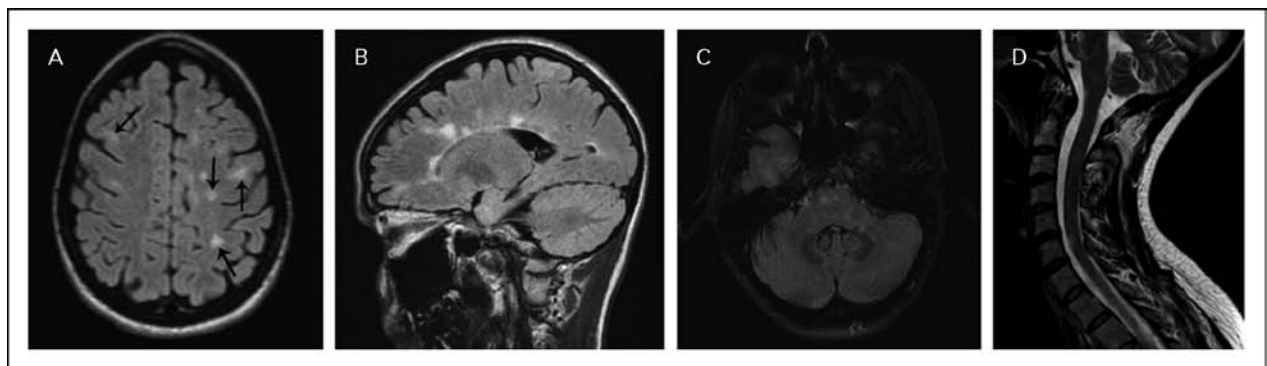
Typical appearance of multiple sclerosis lesions on MRI. (a) Axial FLAIR image demonstrating juxtacortical lesions typical for multiple sclerosis. (b) Sagittal FLAIR image demonstrating periventricular lesions, including in the corpus callosum, giving rise to 'Dawson's fingers' appearance. (c) Axial FLAIR images demonstrating infratentorial lesions seen in multiple sclerosis. (d) Sagittal T2-weighted image of the cervical spinal cord demonstrating lesions seen in multiple sclerosis. Reproduced with permission from [58]. FLAIR, fluid-attenuated inversion recovery.
